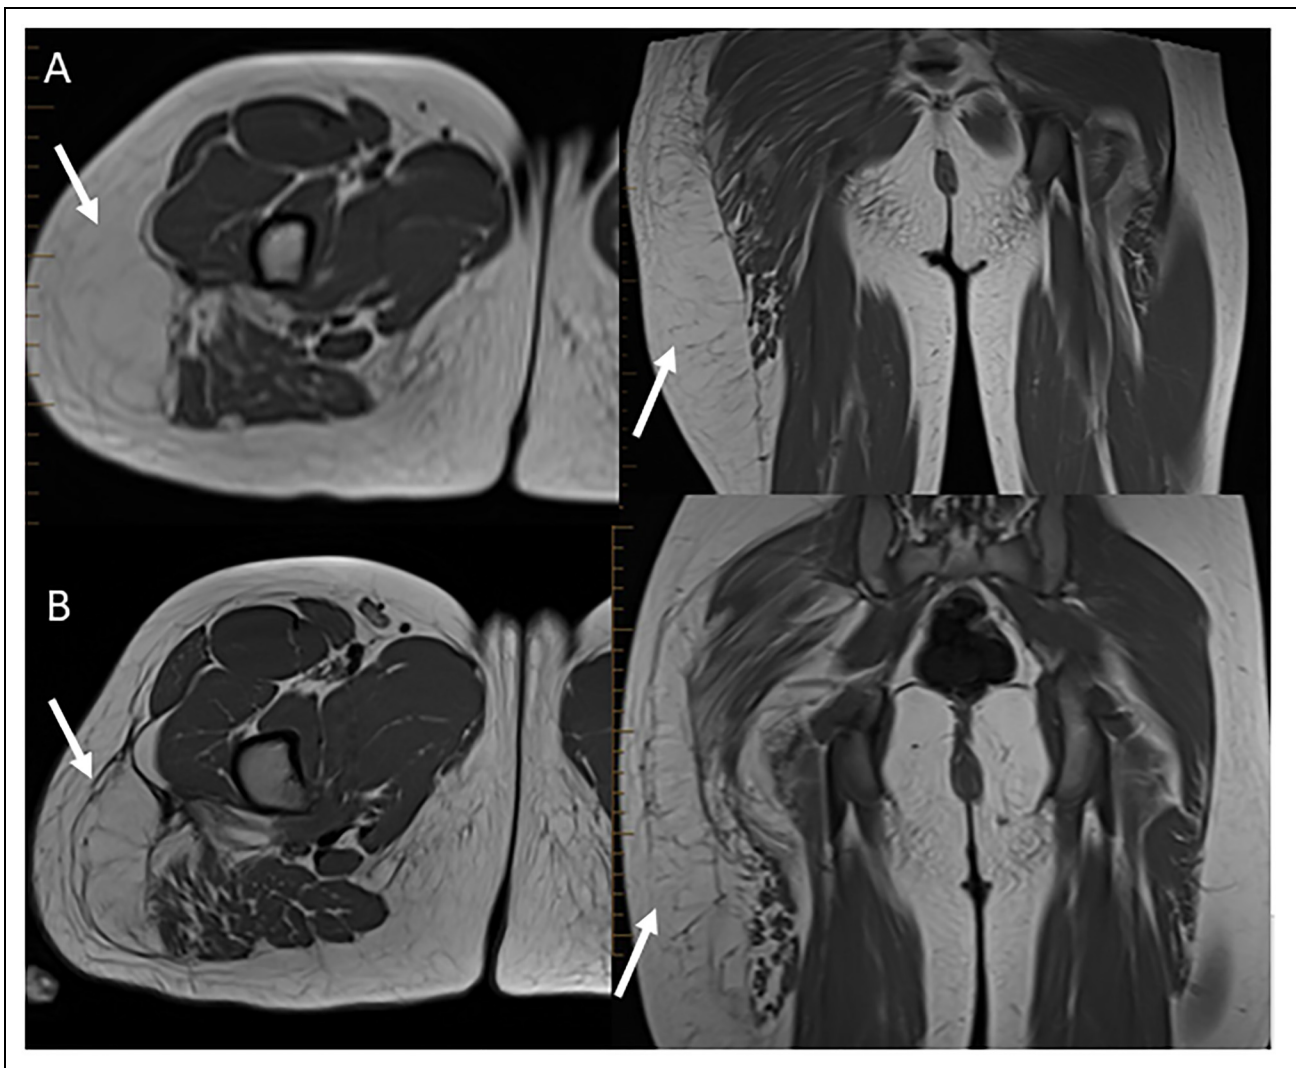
(Patient #1): MRI lower extremity before and after liposuction showing axial and coronal T1 images. Axial and coronal T1 images of the upper right thigh before (A) and after (B) liposuction shows persistent or recurrence of asymmetric prominence of the superficial fatty tissues within the lateral right thigh (short arrows). Similar fatty infiltration of the gluteus maximus and medius muscle (short arrows).
